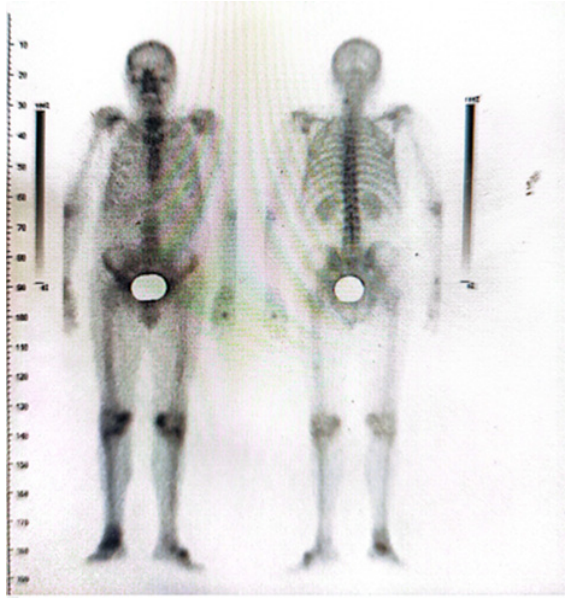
Bone scintigraphy of the patient.
